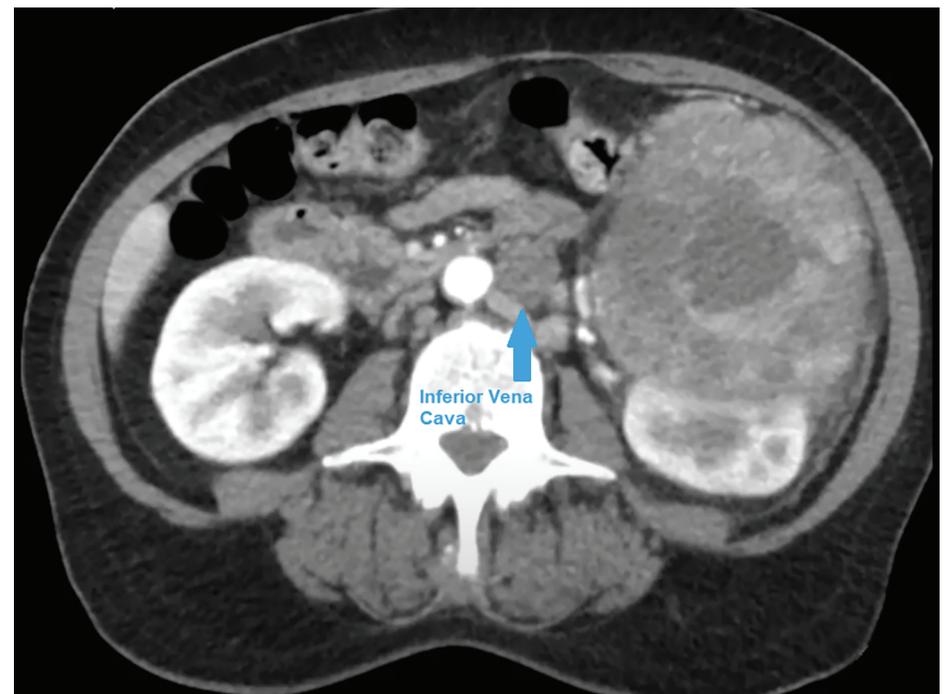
CT of the abdomen and pelvis (axial view) showing a large left-sided renal mass and a left-sided inferior vena cava (arrow).
